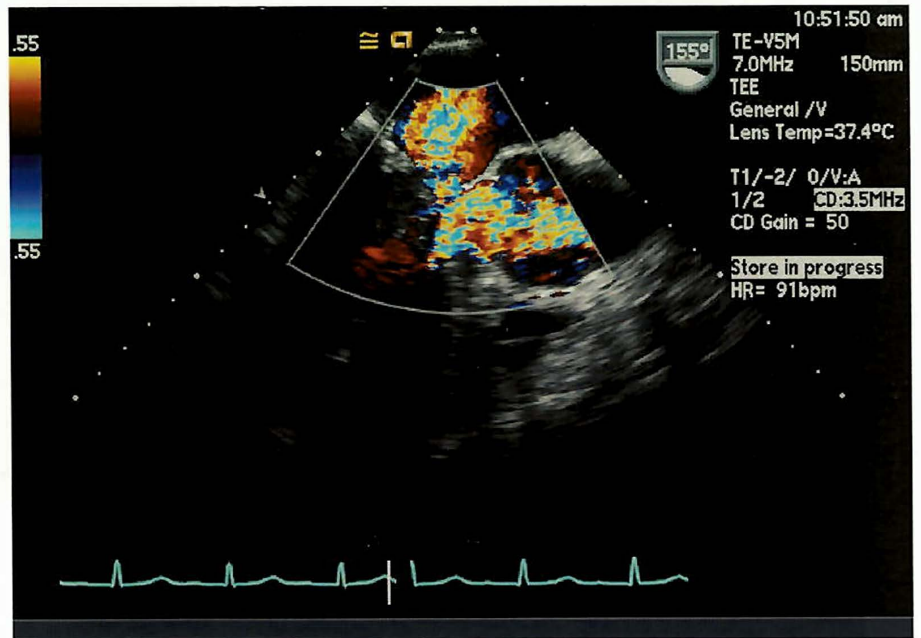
Midesophageal LAX view with color flow Doppler to show mitral regurgitation and left ventricular outflow tract obstruction, both occurring during systole.
